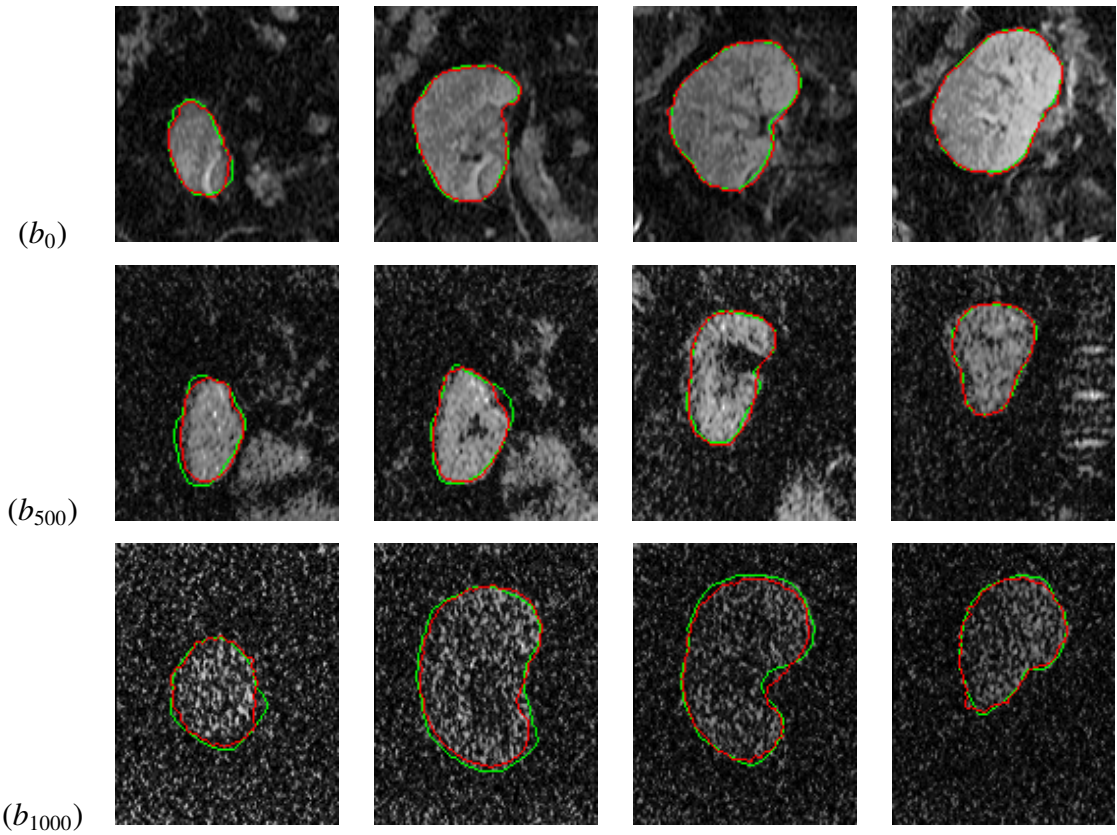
Four more coronal cross-sections (columns) for the proposed kidney segmentation from DW-MRI acquired at different b -values s/mm^2 .
